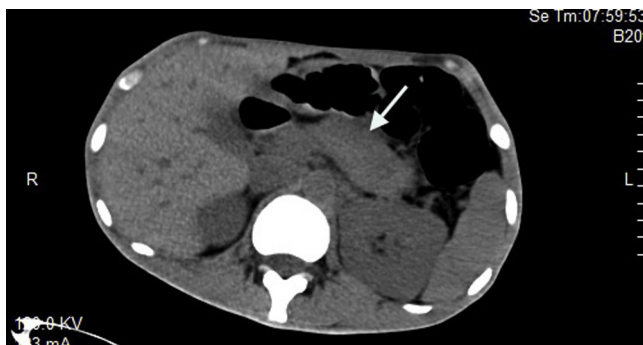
Edematous pancreas in abdominal CT scan.
